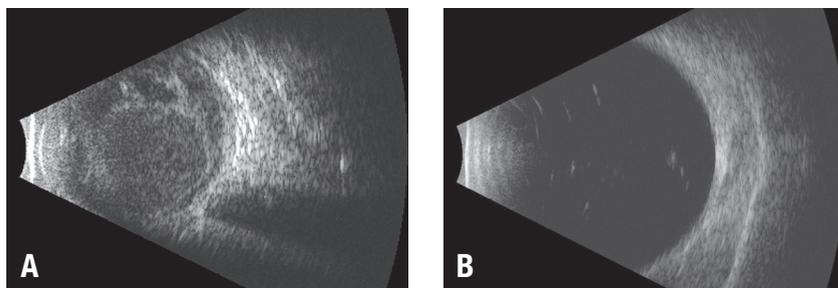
A. B-scan ultrasonography showing dense opacities and membranous debris in the setting of infectious endophthalmitis. B. Mild vitreous opacities in the setting of noninfectious endophthalmitis.
